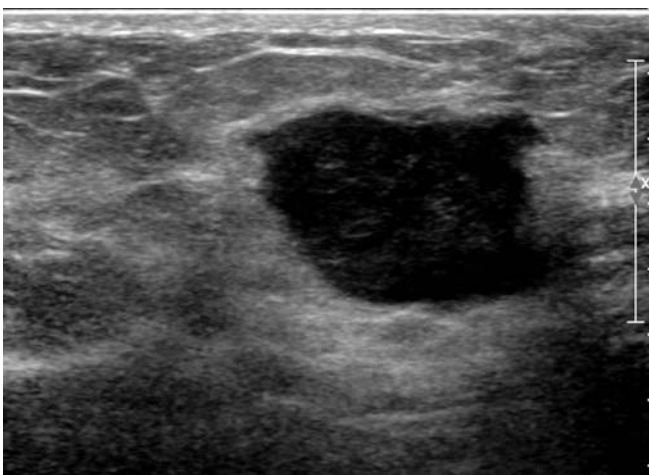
A 63-year-old woman with triple-negative invasive ductal carcinoma. Ultrasound image shows an irregularly shaped, markedly hypoechoic mass with a circumscribed margin in the right breast
